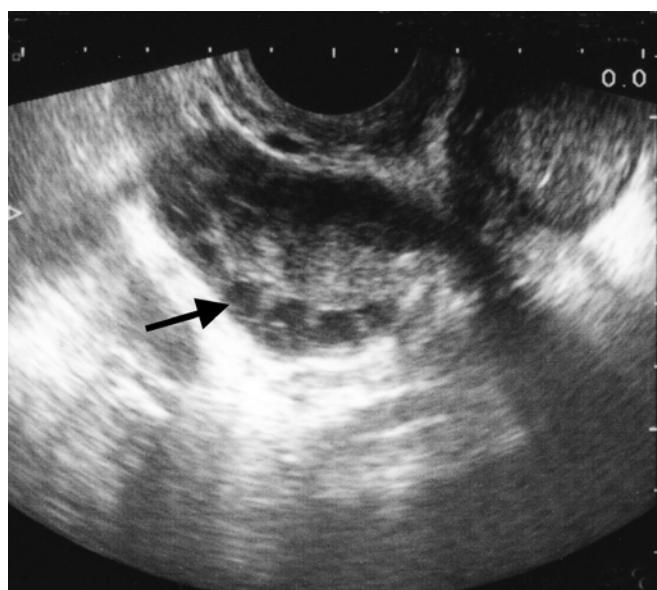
Polycystic ovary syndrome, showing characteristic ultrasonographic appearance of large, mainly peripheral cysts (arrow).
